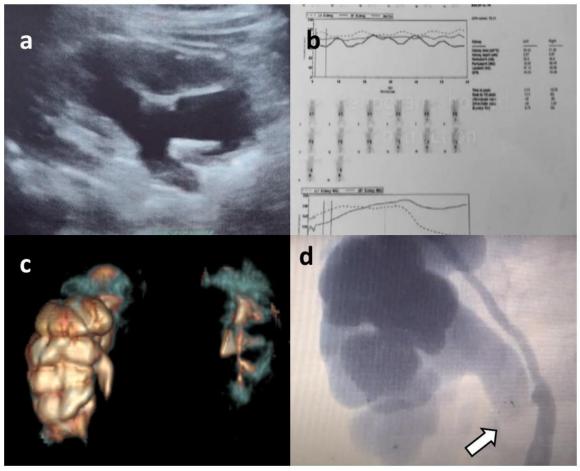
a) ultrasonogram showing lower pole hydronephrosis; b) Diuretic renogram revealing obstructed curve on the right side; c) CT urogram (3D reconstruction) revealing UPJO of lower moiety, but distal ureter anatomy was not seen well; d) retrograde pyelogram revealing UPJO of lower moiety with narrow segment juxtaposed to the Y-junction and little or no distal lower pole ureter (block arrow)
